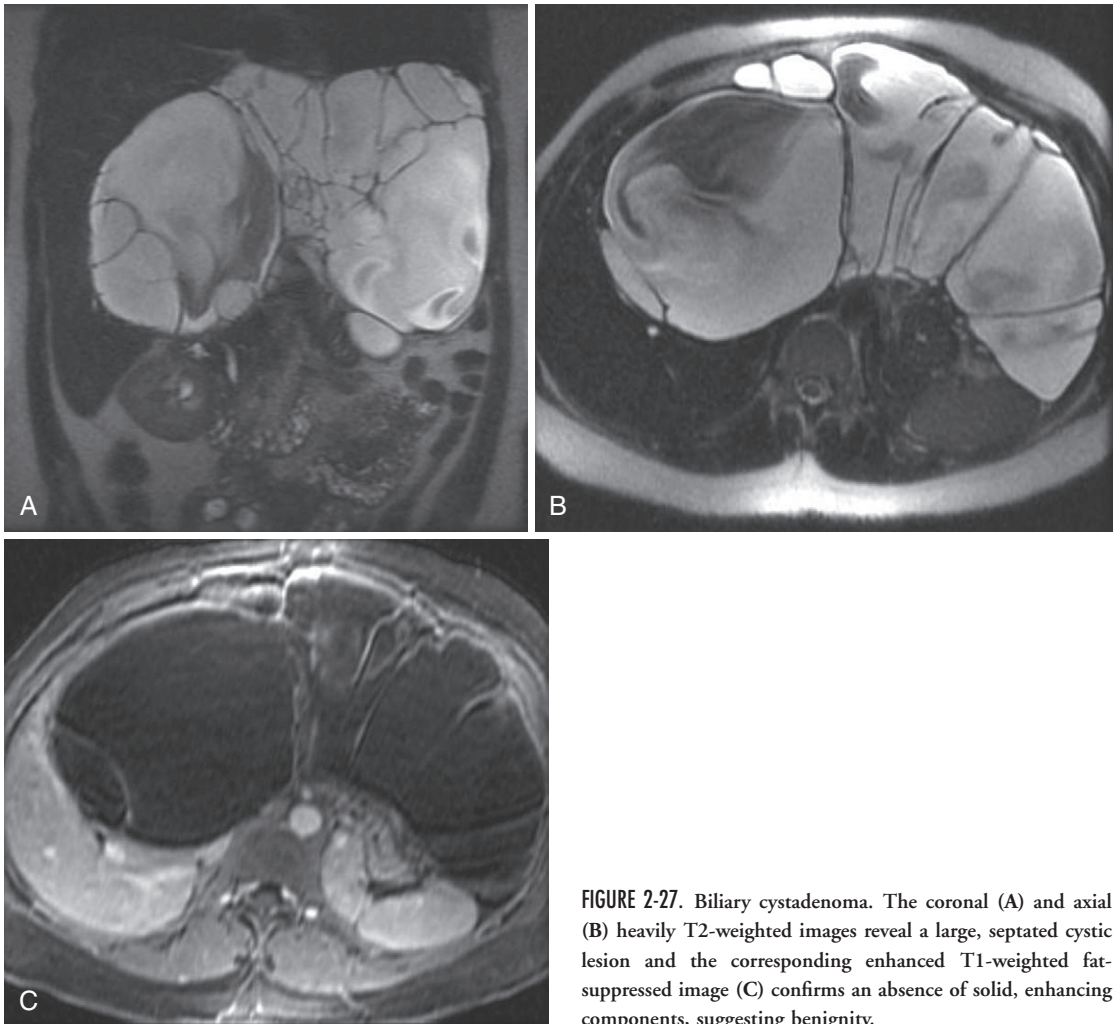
Biliary cystadenoma. The coronal (A) and axial (B) heavily T2-weighted images reveal a large, septated cystic lesion and the corresponding enhanced T1-weighted fat-suppressed image (C) confirms an absence of solid, enhancing components, suggesting benignity.
